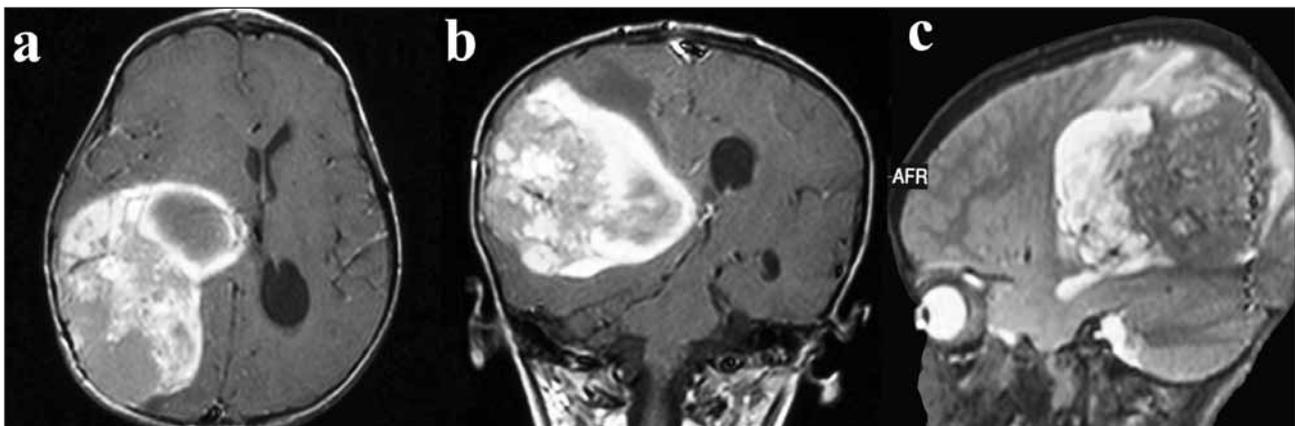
A-C: Preoperative axial (A), coronal (B) and sagittal (C) contrast enhanced cranial MRI sections revealed a right parietooccipital heterogenous enhancing cystic mass (dimensions, 8 x 7 x 6,5 cm) and a midline shift of ~ 1,5 cm.
